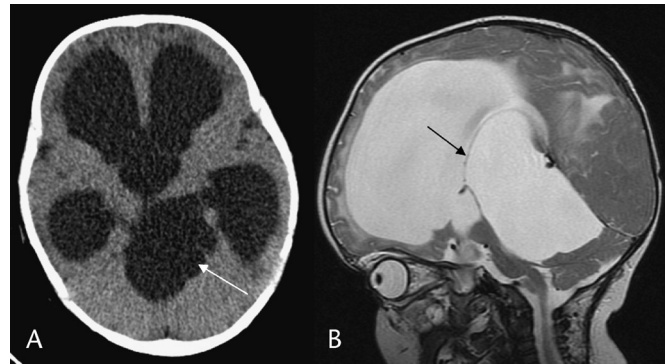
Supracerebellar AC in a 7-month-old boy. Noncontrast CT (A) shows a well-defined CSF-density mass in the upper posterior fossa (white arrow) and marked third and lateral ventriculomegaly. Sagittal T2 image (B) shows the large cyst (black arrow) that displaces/compresses the cerebellar vermis and fourth ventricle inferiorly, and the brain stem and aqueduct anteriorly. It extends through the tentorial hiatus, displaces the straight sinus superiorly, and compresses the posterior third ventricle.
